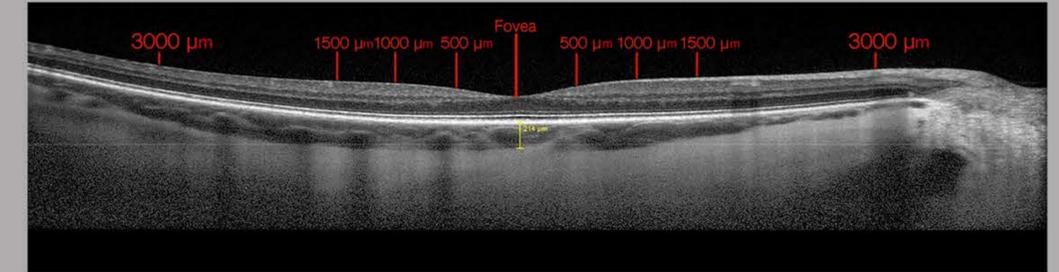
CT measurements
